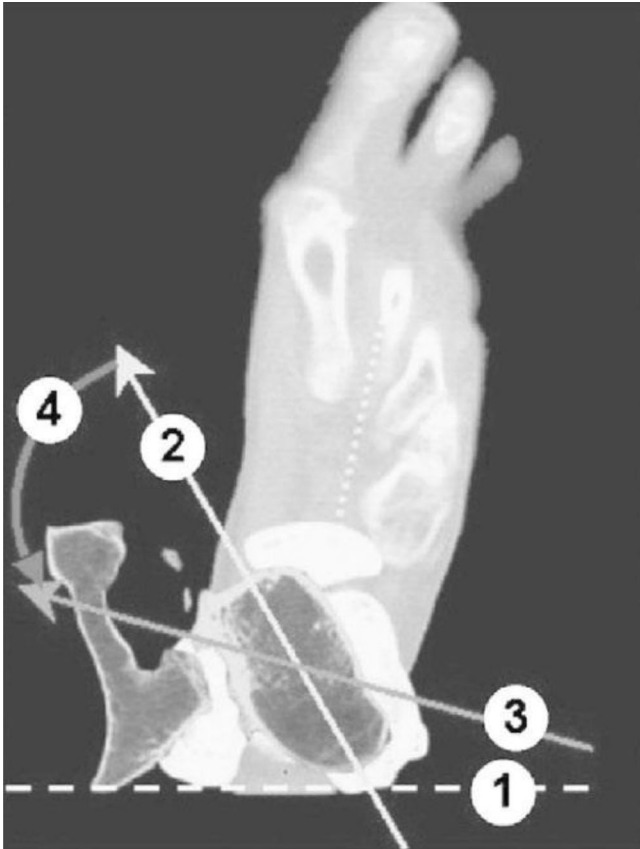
◀ The measurements performed with the CT scan analysis: the bicondylar plan (1), the femoral neck anteversion (2), the desired final prosthetic anteversion (3) and the alpha angle (4) are shown. Cross-sectional horizontal view of the lower limb using CT-scan
